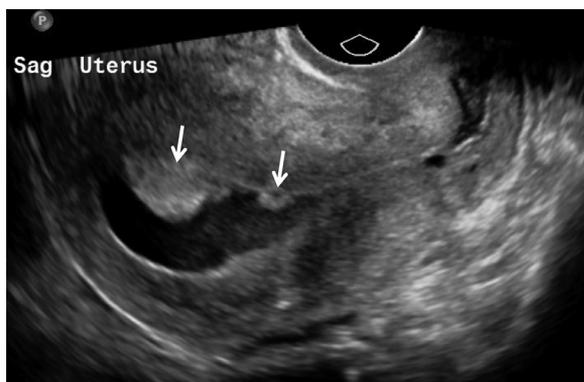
68-year-old female with postmenopausal bleeding. Transvaginal sagittal ultrasound image of the uterus demonstrates a distended endometrial cavity with fluid and 2 solid echogenic lesions (arrows) arising from the endometrium measuring 2.0 cm and 1.1 cm. Patient was submitted to hysterectomy that confirmed endometrial cancer.
